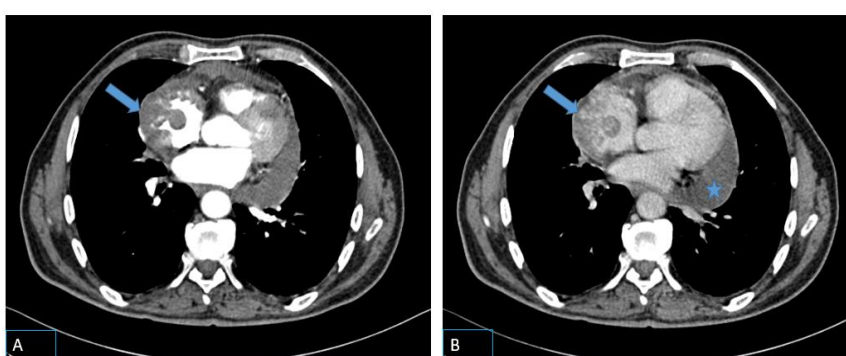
Contrast-enhanced chest CT.
